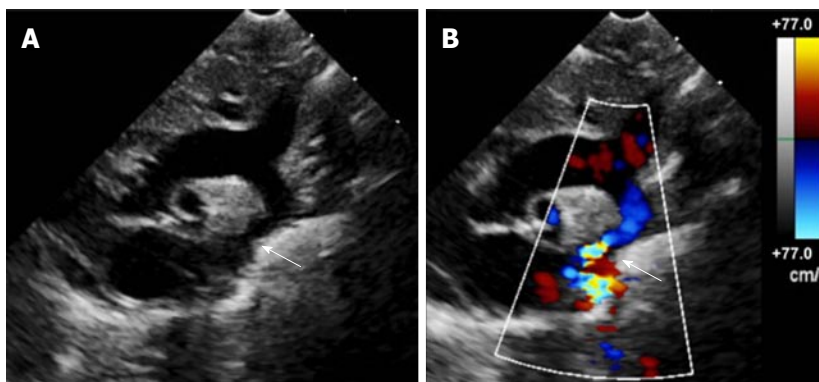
Echocardiogram of coarctation. A: Two-dimensional transthoracic echocardiogram image obtained from the suprasternal notch in an 11-day-old infant demonstrating discrete coarctation (arrow); B: Color Doppler of the same image with aliasing of flow at the site of coarctation (arrow).
